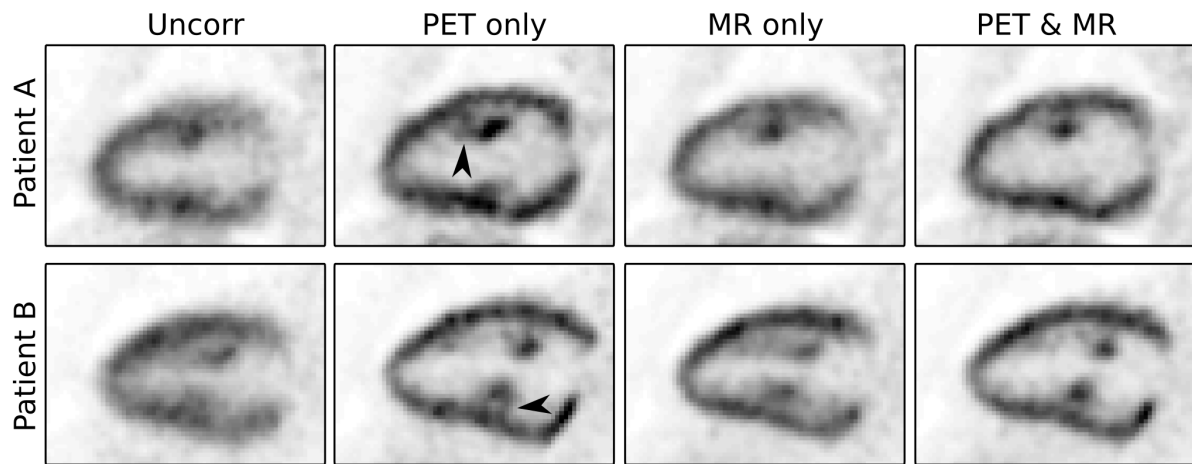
Long-axis slices of two patients comparing PET images without motion correction (Uncorr) and with cardiac and respiratory motion correction using motion fields obtained using only PET images (PET only), using only MR images (MR only) and the proposed joint PET-MR motion estimation (PET & MR). Artefacts (black arrows) and residual motion blurring is visible for motion correction based on PET only and MR only images.
